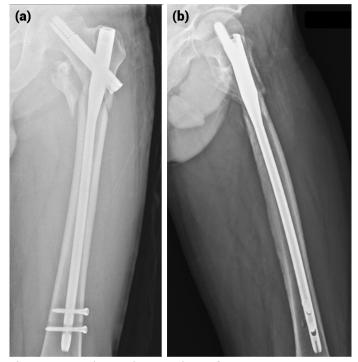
AP and Lateral X-RAY views of LPFNA.
